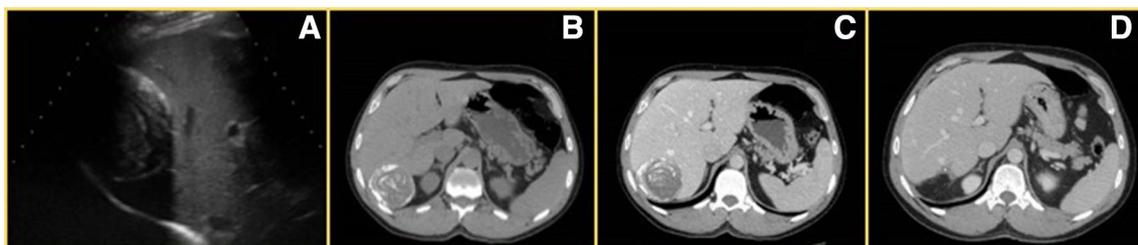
CT typical features of hydatid cyst: round lesion with water attenuation density, surrounded by calcific ring (a, b), containing laminated—linear areas of increased attenuation
